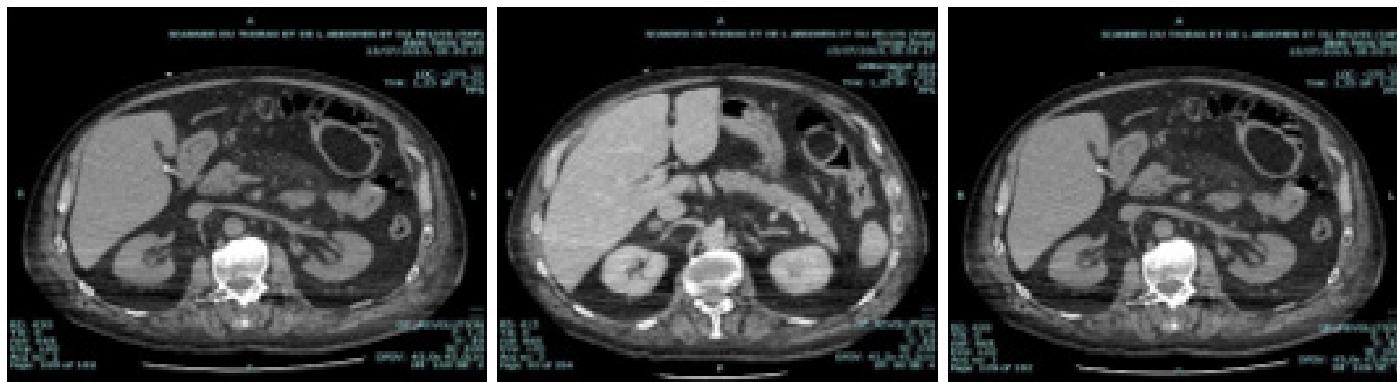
CT showing a large transverse colon lipoma with intussusception.
